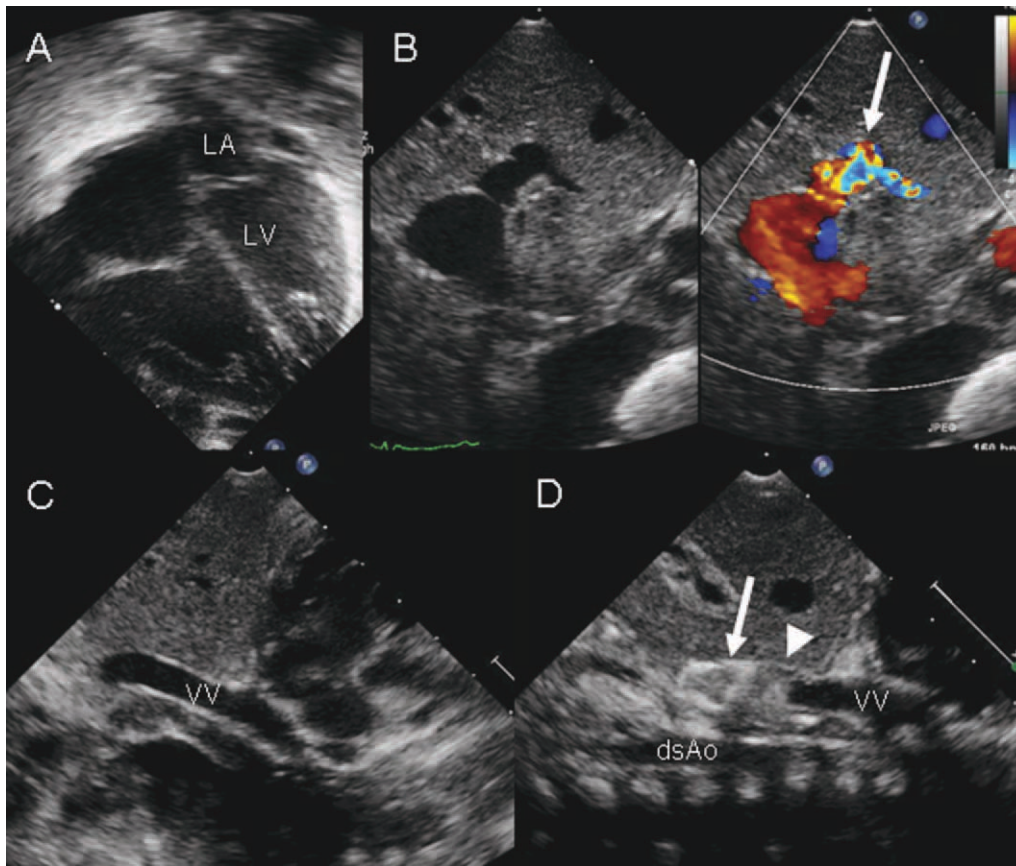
Echocardiography before and after device closure of the descending unligated vertical vein (A) Apical four chamber view at initial presentation, showing the hypoplastic left atrium (LA) and left ventricle (LV). (B) Subcostal short-axis view an initial presentation, showing the confluence of the descending vertical vein (VV) and portal vein. Doppler interrogation of portal vein showed increased flow velocity suggesting obstruction (arrow). (C) Subcostal long-axis views before transcatheter
